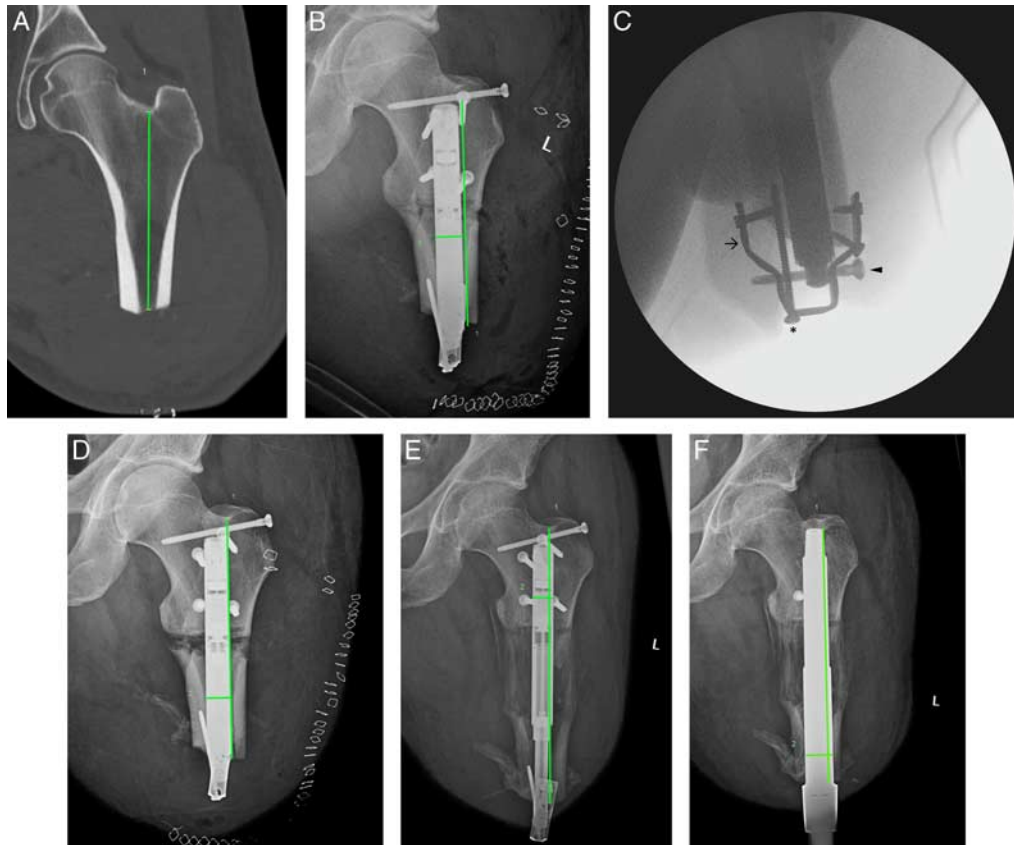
Contoured locking plate technique. This patient was a 46-year-old male transferred to our hospital several weeks after having bilateral transfemoral amputation performed after sustaining a farm injury. The right femur was sufficiently long for a standard osseointegration implant, but the left was not. A, Templating computed tomography Line 1 from piriformis fossa to distal bone end measured 124 mm, shorter than the 130 mm lengthening nail. The goal was to achieve a 140 mm long canal (a gain of 16 mm). B and C, A one third tubular locking plate (indicated by arrow) was contoured around the distal femur which allowed one screw (indicated by arrowhead) to capture the distal limb lengthening nail (LLN) hole. One long intracortical screw (indicated by asterisk) and 3 additional unicortical screws linked the nail to the distal bone segment. The routine postoperative lengthening protocol was initiated but lengthening immediately caused severe pain without length gain. D, Direct inspection of the construct identified that one of the screws securing the plate to the distal segment cortex interfered with a telescoping segment of the nail. The screws were repositioned and a new nail was placed. Elongation was confirmed in situ before closure. E, Further lengthening was uneventful to 164 mm. F, The LLN was exchanged for an osseointegrated prosthetic limb 19×160 mm 112 days after LLN insertion. Currently, 11 months following his LLN surgery, no other setbacks have occurred.
